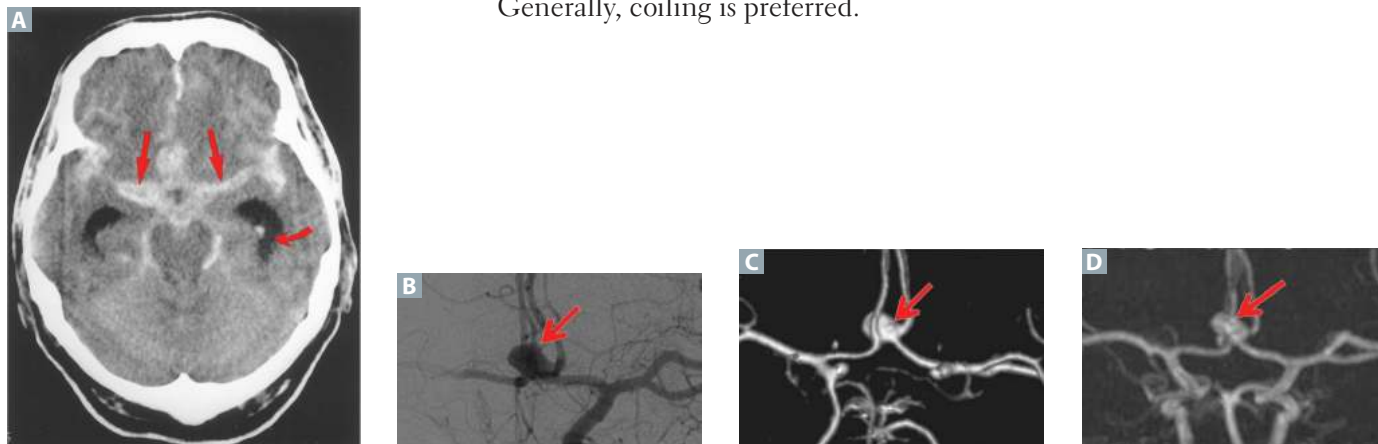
Subarachnoid hemorrhage. Noncontrast CT (A) showing SAH filling the basilar cisterns and sylvian fissures (*straight arrows*). The *curved arrow* shows the dilated temporal horns of the lateral ventricles/hydrocephalus. Images from a catheter angiogram (B), a CT angiogram (C), and an MRA (D) show a saccular aneurysm arising from the anterior communicating artery (*arrows in B, C, and D*).
